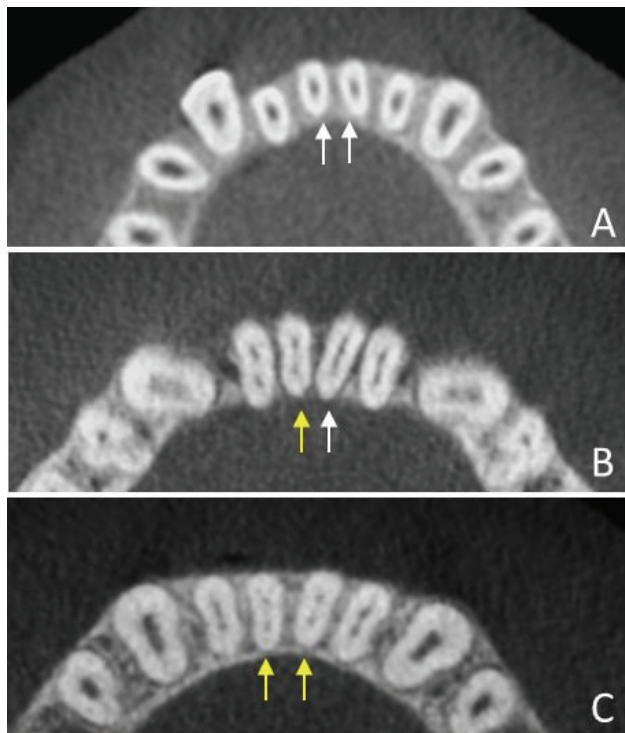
The root canal configuration of a ManCI in an axial CBCT image. (A) Bilateral single root canal configuration, (B) unilateral complicated root canal configuration, and (C) bilateral complicated root canal configuration (yellow arrows show RE; white arrows show no RE)
